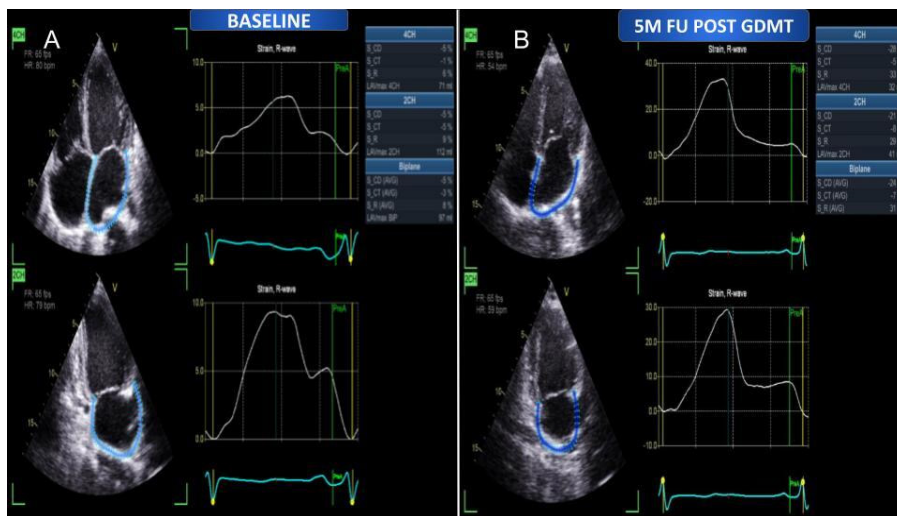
Transthoracic Echocardiography LAS analysis. Left panel: Baseline LAS measurement; Right panel: Post-treatment LAS evaluation showed significant improvement. LAS: left atrial strain.
